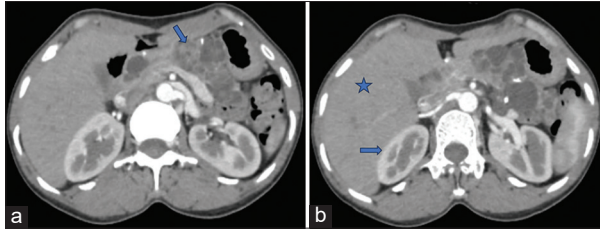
(a) Contrast-enhanced computed tomography whole abdomen showing multiple hypodense variable-sized cysts throughout the head, body, neck, and tail of the pancreas (arrow), (b) Normal liver (star) and kidneys (arrow) parenchyma with no cystic lesion
